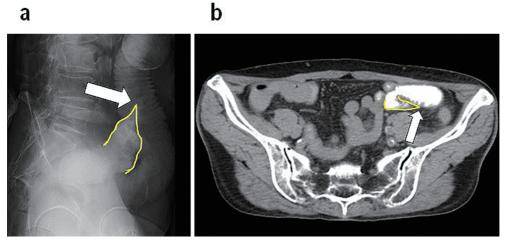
Radiological findings of case 1. (a) Fluoroscope imaging; white arrow shows obstruction point and beak sign (yellow color's line). (b) CT imaging; white arrow shows obstruction point and beak sign (yellow color's line).
